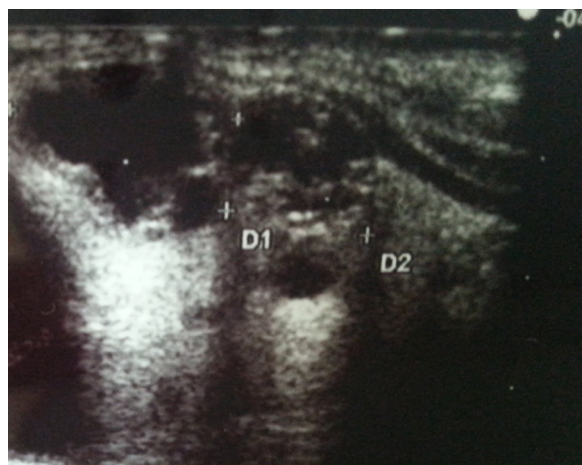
Ultrasound appearance of two echo-free thyroid cysts with posterior shadow.
